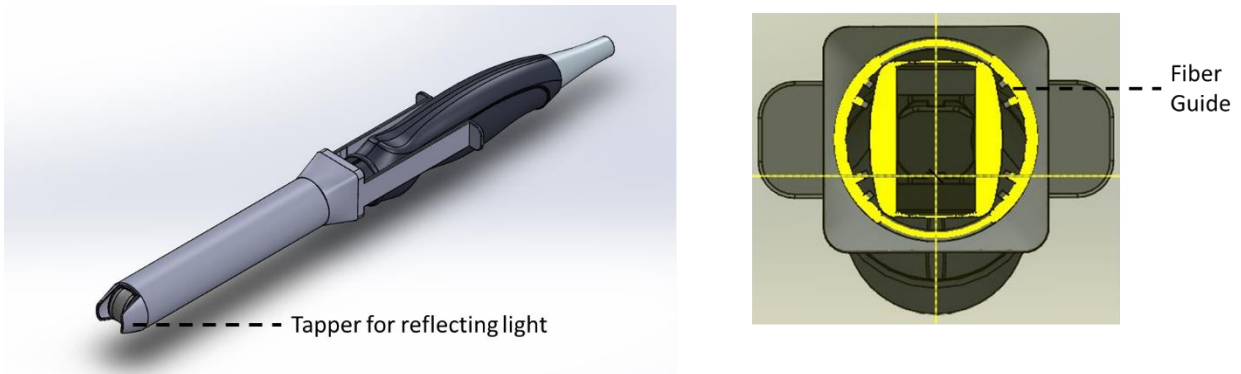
6 3D printed handheld probe for holding optical fiber around ultrasound transducer
